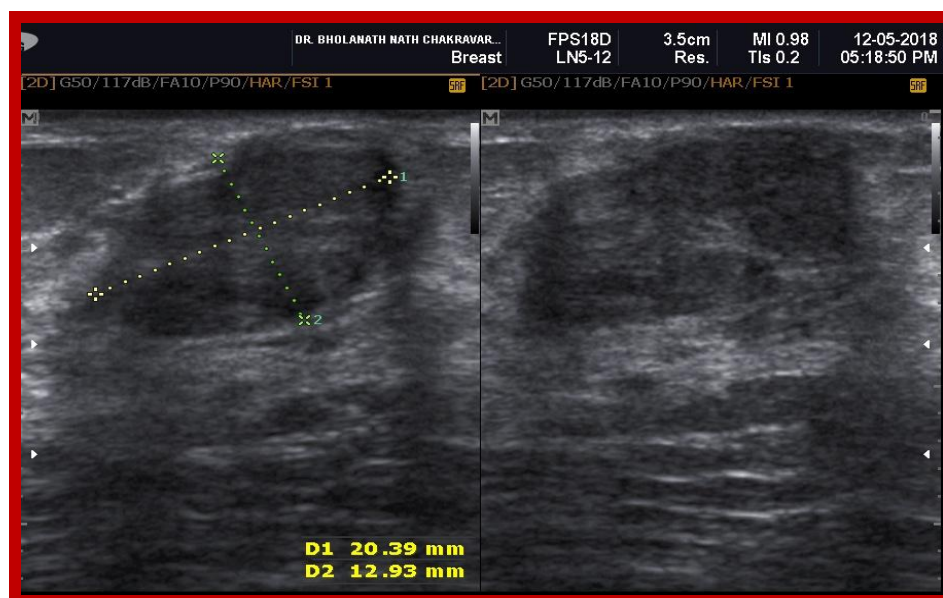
The visualized sonographic image region reveals a focal bulge of homogeneous soft tissue density of size approximately 20.39mm x 12.93mm, suggestive benign SOL with smooth margins
